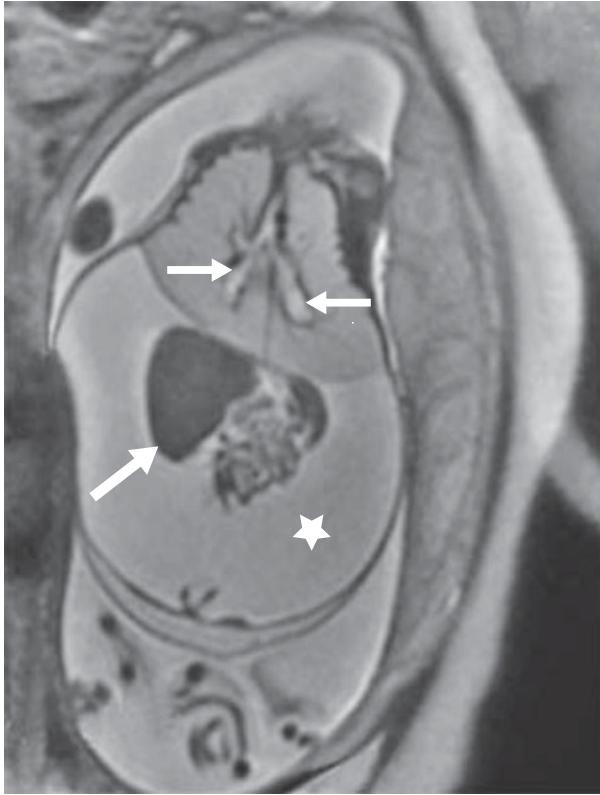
Fetal ultrasonography at 27 weeks' gestation demonstrating findings consistent with the diagnosis of congenital high airway obstruction: enlarged echogenic lungs, dilated airway (white arrow), flattened or everted diaphragms, and fetal ascites (white star) and hydrops. Fetal liver and intestines marked with a black arrow.
